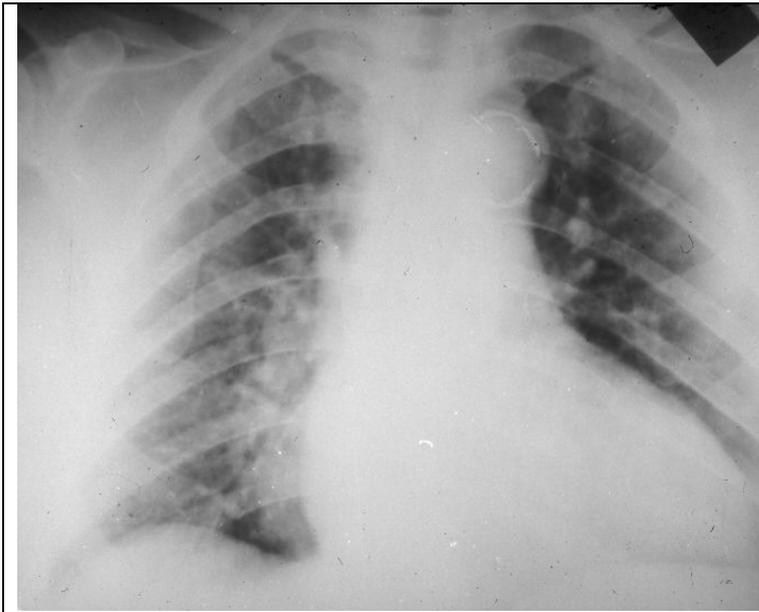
The frontal chest radiograph. The first and fourth arches on the left contour are increased. Calcification of aorta arches. Aortic configuration of the heart.
